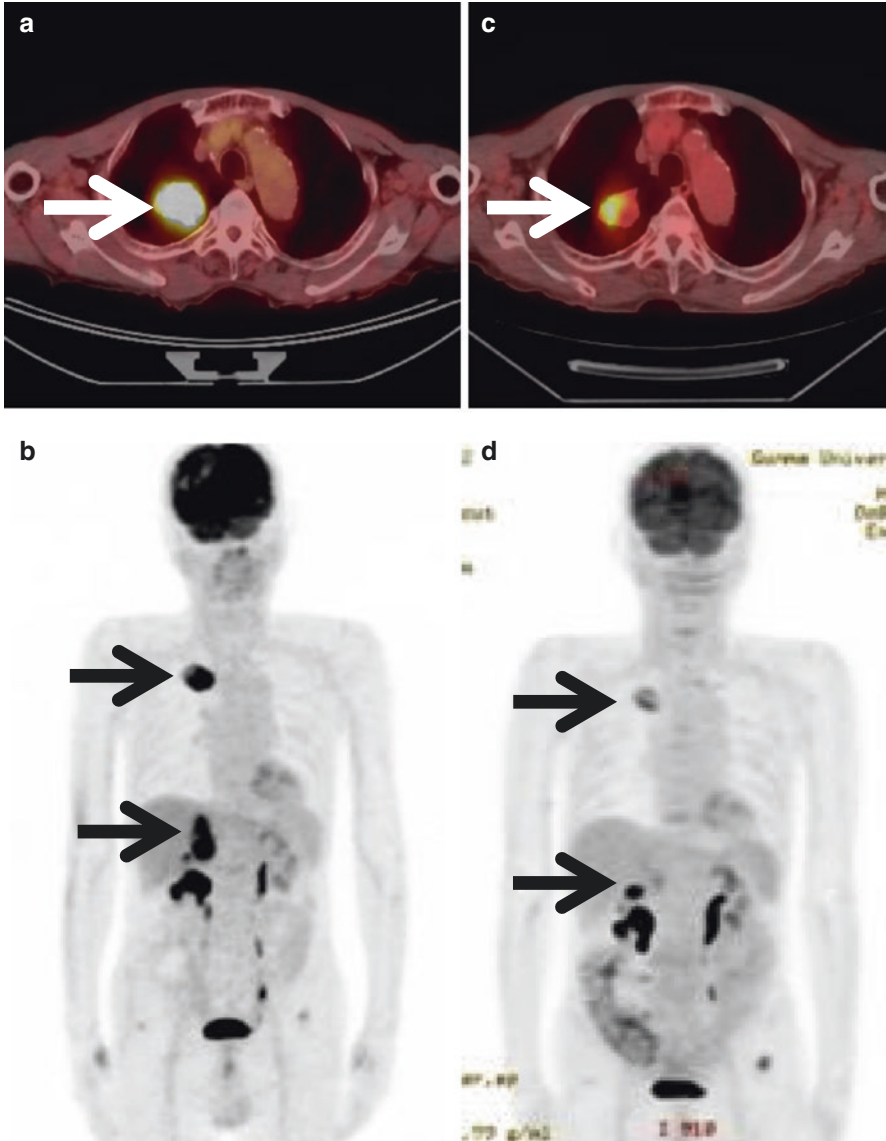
A 74-year-old male with pulmonary squamous cell carcinoma who received nivolumab because of recurrence after platinum-based chemotherapy as first-line. PET imaging shows markedly decreased uptake of FDG in the primary site (white and black arrow) and right adrenal metastatic site (white arrow) between before (a, b) and after 1 month (c, d) from nivolumab initiation. The values of SUV_{max} in the primary and metastatic sites are 12.0 and 10.5, respectively, before nivolumab treatment, and 5.5 and 3.8, respectively, at 1 month after nivolumab
